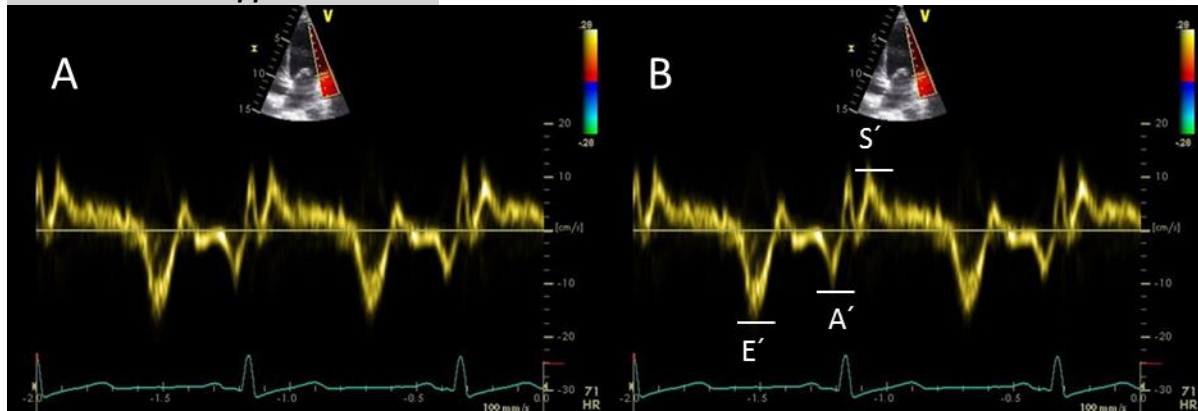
Tissue Doppler lateral MV (A) and measurement of tissue Doppler lateral MV (B)
